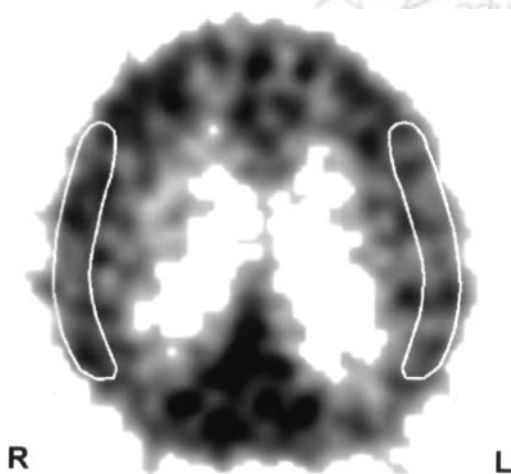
ROIs drawn on cortical territories of MCAs in bilateral hemispheres at level of centrum semiovale with reference to individual MR images. Time-activity curves for H_2^{15}O PET scans and regional values in parametric images were obtained using the same ROIs for each subject.
